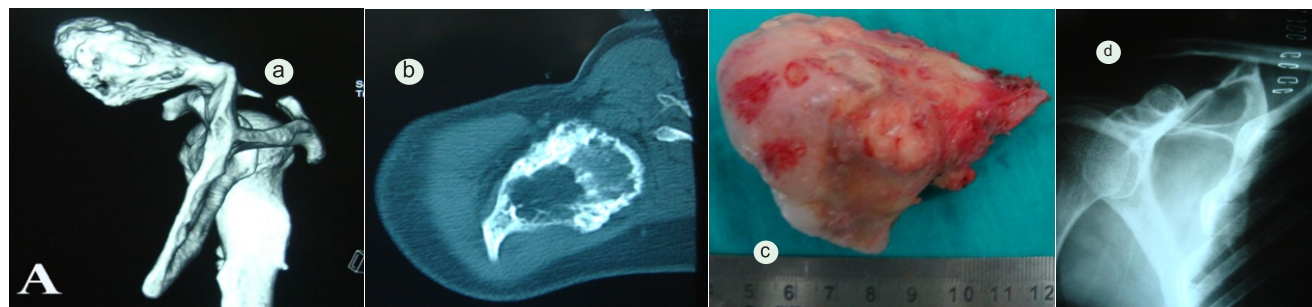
a- A CT scan of right shoulder joint shows a large pedunculated lytic bony lesion originating from the medial aspect of the superior margin of right scapula. The mass measures 6.2x5.0 cm in size. The tumour shows speculated sclerosed margins with no cortical break. Similar but smaller lesions are also seen involving the upper shaft of right humerus. b- Axial CT image of the lesion. c- A photograph showing the measurement of the tumour. Gross examination of the excised tumour shows irregular surface along with its stalk with characteristic bluish gray cap of cartilage. d- final radiograph confirming complete removal of tumor.
